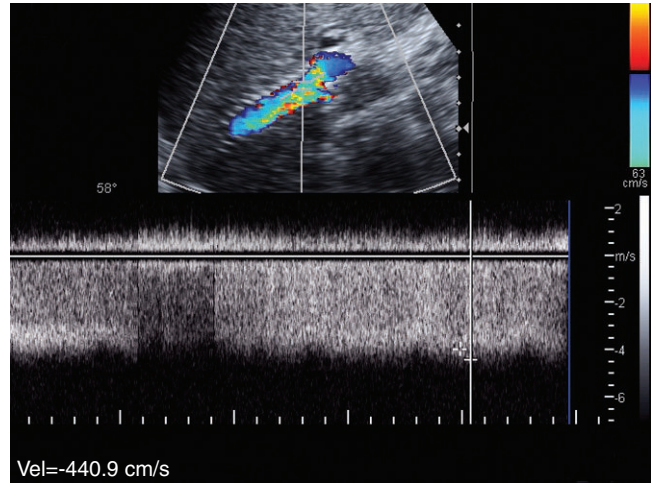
The longitudinal duplex and color Doppler image of the stent graft shows an elevated velocity of 441 cm/second in the area of aliasing indicative of a stenosis. The normal range for stent graft velocity is 90-190 cm/second.
